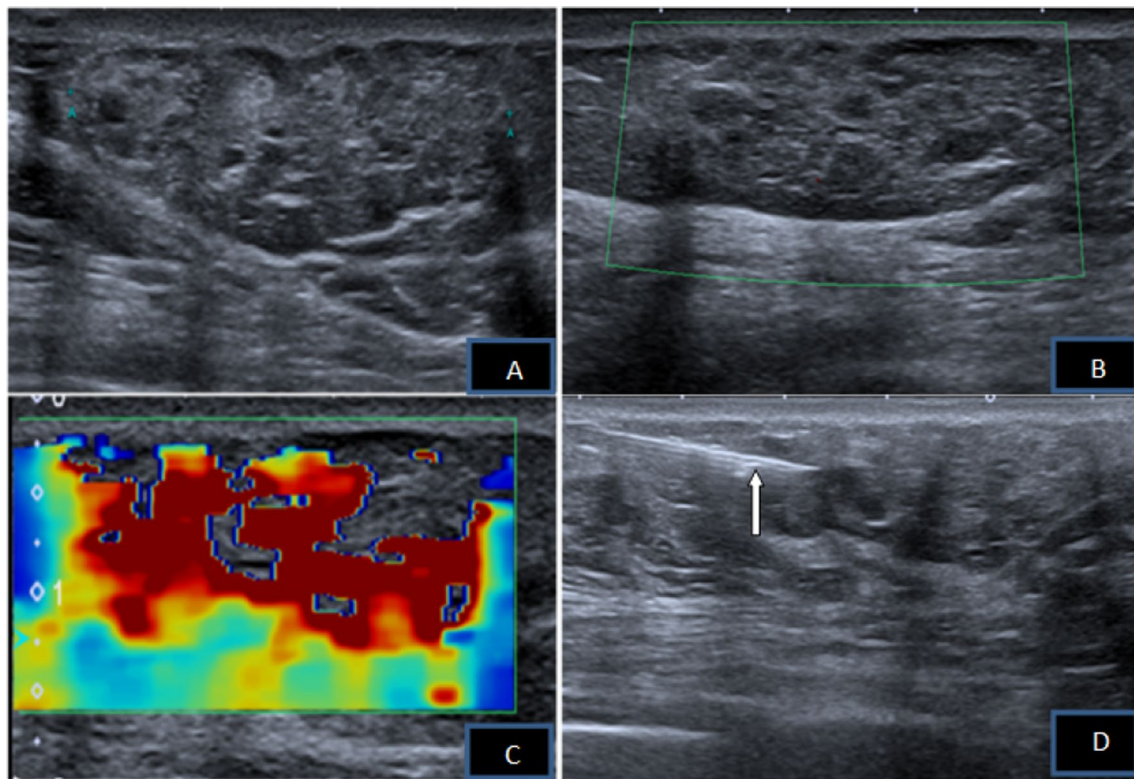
A, B: shows a well circumscribed oval parallel oriented solid heterogeneous lesion with no posterior features and absent vascularity. C on shear wave elastography the lesion shows increased stiffness. D. Ultrasound guided core biopsy with needle in situ (arrow)
